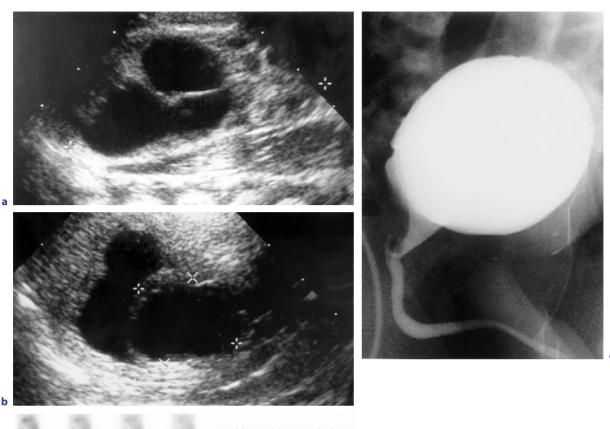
Antenatal diagnosis of hydronephrosis found to be due to bilateral VUR with upper-tract dilatation and a normal bladder outflow. a Postnatal ultrasound at 1 week of age shows a dilated renal pelvis of the left kidney with calyceal dilatation on the longitudinal cuts. b Transverse scan of the left kidney on the same examination also shows a dilated renal pelvis. c The longitudinal scan of the right kidney shows a similar dilatation. There were dilated ureters seen behind the bladder which was not thick-walled (not shown). d The VCU shows bilateral reflux into both pelvicalyceal systems which are dilated. The bladder is smooth walled. The urethra was normal (not shown). e Tc99m DMSA scan at 3 months of age fails to show any focal abnormality, there is slightly reduced function in the left kidney compared to the right. f The curves of the dynamic Tc99m MAG3 scan show the right kidney functions slightly better and drains more promptly than the left kidney
